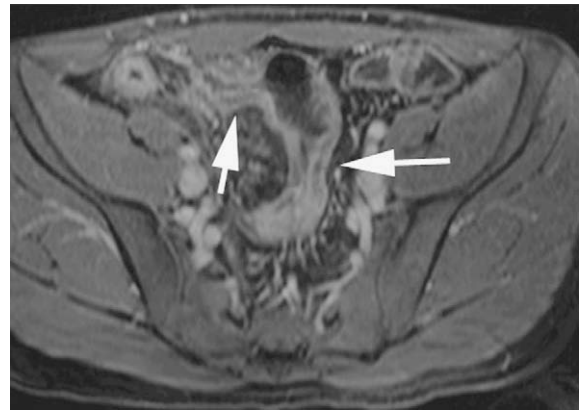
A 33-year-old man with CD and obstructive symptoms. Contrast-enhanced, axial, T1-weighted, 3D source image obtained with volumetric interpolated breath-hold examination ($5.3/2.4/10^\circ$, 2.5 mm section thickness) shows multiple strictures in the distal ileum (arrows). The strictures show minor, inhomogeneous contrast enhancement and hypointense signal is seen in the submucosal layer indicative of fibrosis. Note lack of oedema or inflammation in the surrounding mesenteric fat.
